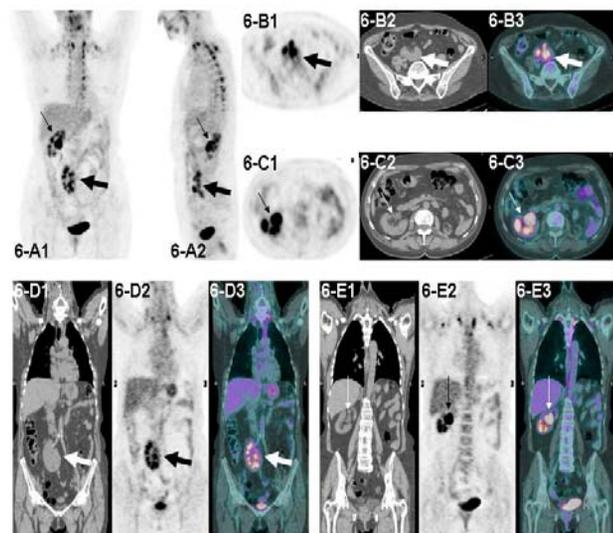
Anterior view (5-A1) and left lateral view (5-A2) of maximum intensity projection image show ectopic left kidney (big arrow) and normal right kidney (slim arrow); axial PET (5-B1), CT (5-B2), fused (5-B3) images show left ectopic kidney (big arrows); axial PET (5-C1), CT (5-C2), fused (5-C3) images show right kidney (slim arrows); coronal CT (5-D1), PET (5-D2), fused (5-D3) images show left ectopic kidney (big arrows);
